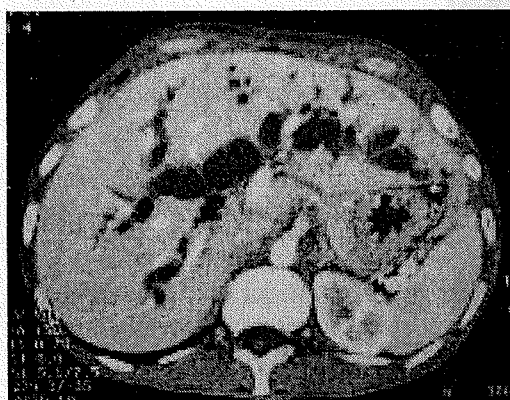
(a) : Axial CT image shows gross dilatation of IHBR in both lobes of liver.
